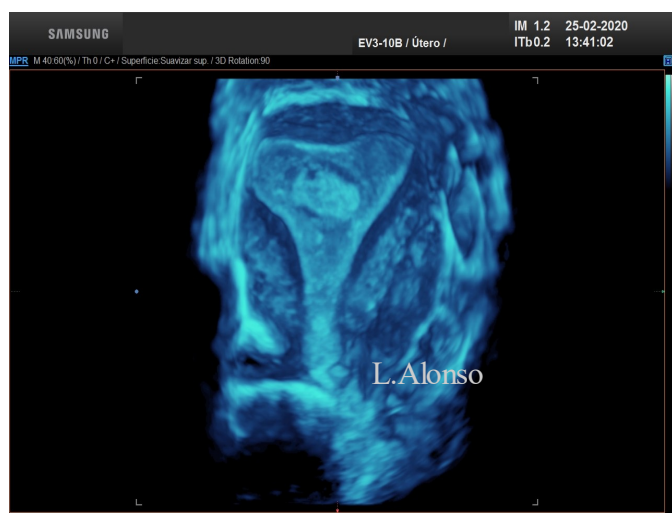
3-dimensional transvaginal ultrasound image show endometrial polyp in back wall of uterine body.
